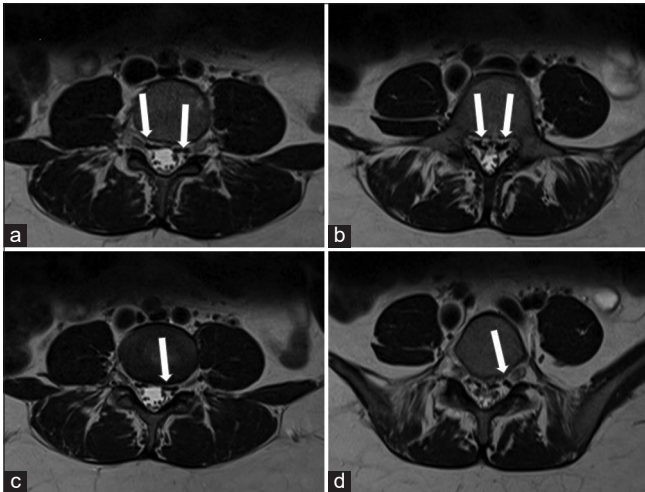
T2-weighted axial MRI (a-d) shows enlarged lumbar epidural plexus (white arrows) compressing the nerves roots through the foramina.
